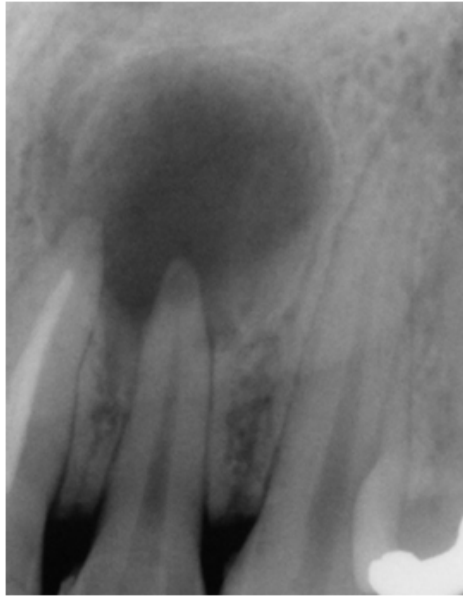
Radiological features of a typical periapical cyst [60].
